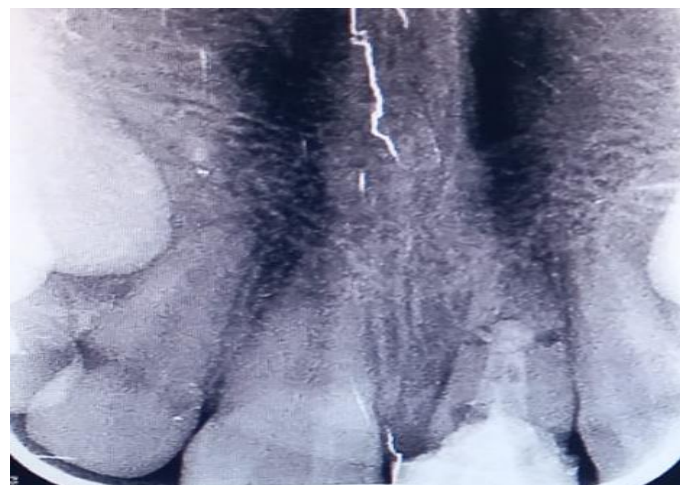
Fiber-post final radiographic image.
